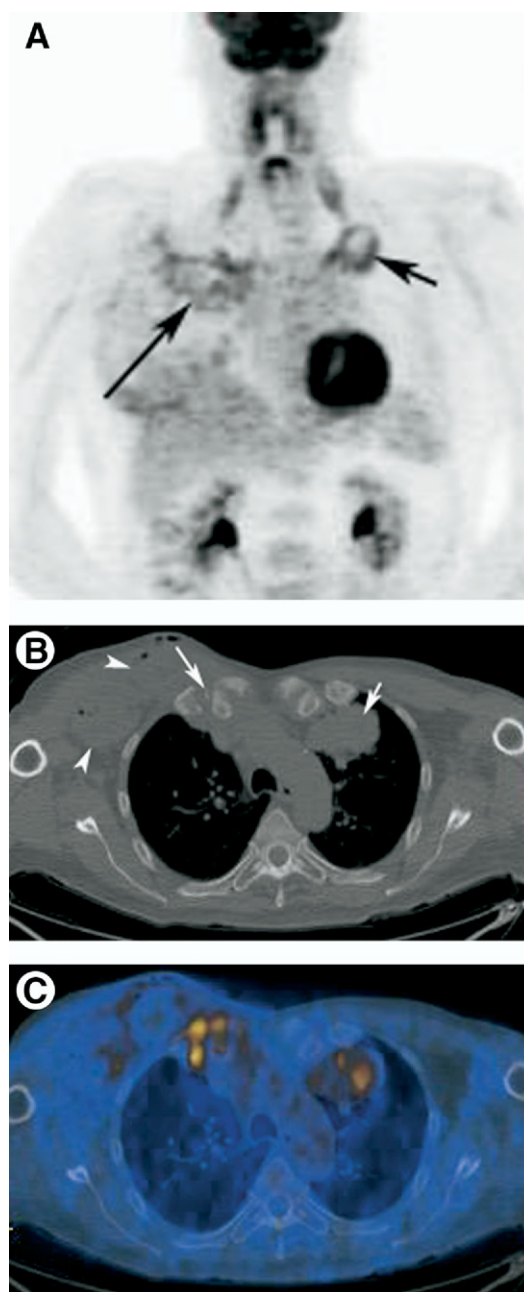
A 75-year-old man with adenocarcinoma of the left upper lobe. In addition, the patient presented with an abscess in the right thoracic wall. (A) Maximum intensity projection (MIP) demonstrates circular increased FDG uptake in the left upper lung (short arrow) as well as diffuse FDG uptake in the right upper hemithorax (long arrow). Physiological FDG uptake is seen in the scaleni muscles as well as in the larynx. (B) Axial CT scan demonstrates the lung tumor in the right upper lobe (short arrow) and a tumorous lesion subpectoral (arrowheads) in the right thoracic wall with air and involvement of the right sterno-clavicular joint (long arrow). (C) Axial PET/CT scan shows increased FDG uptake in the bronchial carcinoma in the left upper lobe. In addition, circular increased FDG uptake is found in the tumorous lesion in the right hemithorax representing the abscess as well as focally increased FDG uptake of the right sterno-clavicular joint and the adjacent bones with osseous destruction. In addition, the right sternocostal joint was involved. In contrast to PET or CT imaging alone, coregistered PET/CT helps to diagnose soft tissue infection and additional infectious involvement of the adjacent bones.
